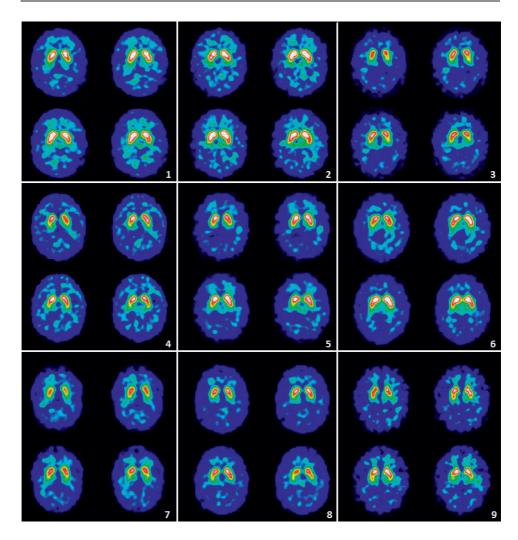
Nine [123I]FP-CIT SPECT scans of patients with abnormal scan analyses in the expert visual analysis but normal scans in the automated semi-quantitative BRASS analysis. The color scale indicates SBRs of striatal DAT binding and the scale bar previously presented in Figure 4.
